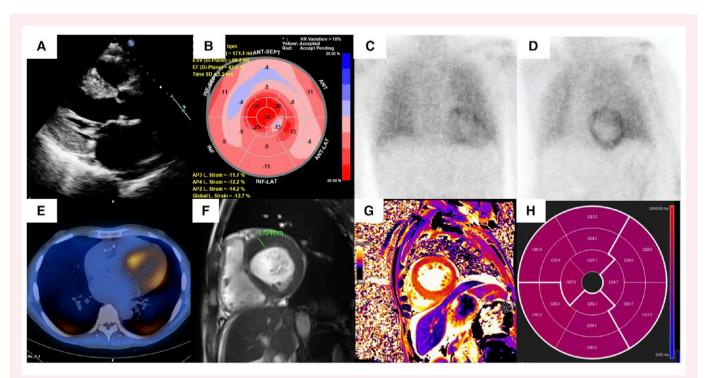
(A) Echocardiography revealed severe concentric left ventricular hypertrophy with a maximal end-diastolic wall thickness of up to 16 mm and minimal pericardial effusion. (B) A speckle-tracking analysis demonstrated a reduced longitudinal strain in the LV with a relatively sparing pattern at the apex. (C, D, and E) A  $^{99m}$ Technetium-Pyrophosphate Planar and single-photon emission computed tomography (SPECT) scan revealed a grade 3 uptake within the myocardium. (F) CMR showed that the maximal end-diastolic wall thickness was 15.4 mm at the anteroseptal segment. (G and H) Native T1 mapping revealed that the mean native myocardial T1 value was  $1244 \pm 74$  ms (normal range, 1156-1355 ms; 3-Tesla Vida MR scanner, Siemens Healthcare, Erlangen, Germany). An ATTR cardiomyopathy was less likely.
